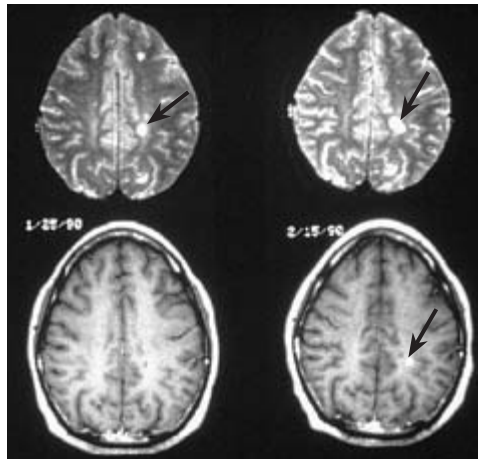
Paired transverse MRI slices from the brain of a patient with MS. (Top) T₂-weighted slices showing characteristic high-signal white-matter lesions (arrows) and revealing the burden of disease over time. (Bottom) T₁-weighted slices, with gadolinium contrast enhancement of one of the lesions (arrow) indicating permeability of the blood-brain barrier. Enhancing lesions correlate pathologically with perivenular inflammation and are considered a surrogate marker of disease activity.
